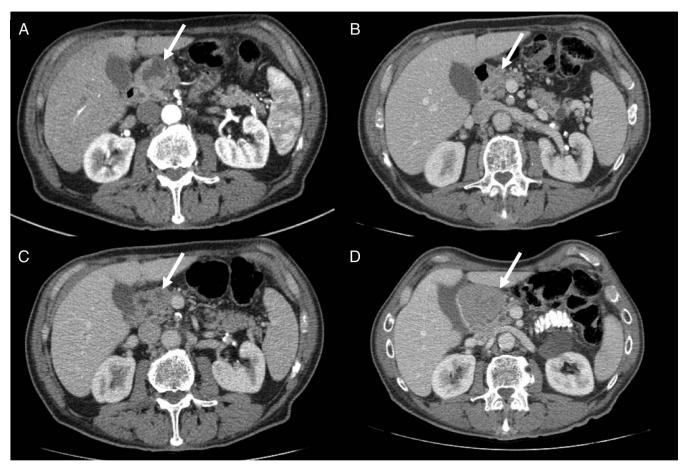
(A) 3.0×2.7 -cm pancreatic head acinar cell carcinoma identified incidentally on computed tomography. (B) Significant interval reduction of mass to 0.8×0.6 cm after 6 months after 4 EUS chemoablations and 4 months of systemic chemotherapy. (C) Stability in treatment response $(0.9 \times 0.9 \, \text{cm})$ at 12 months after 6 EUS chemoablations and 8 months since last systemic chemotherapy. (D) Increase in size to 6×4.5 cm at 24 months after initial EUS chemoablation. EUS, endoscopic ultrasound.
